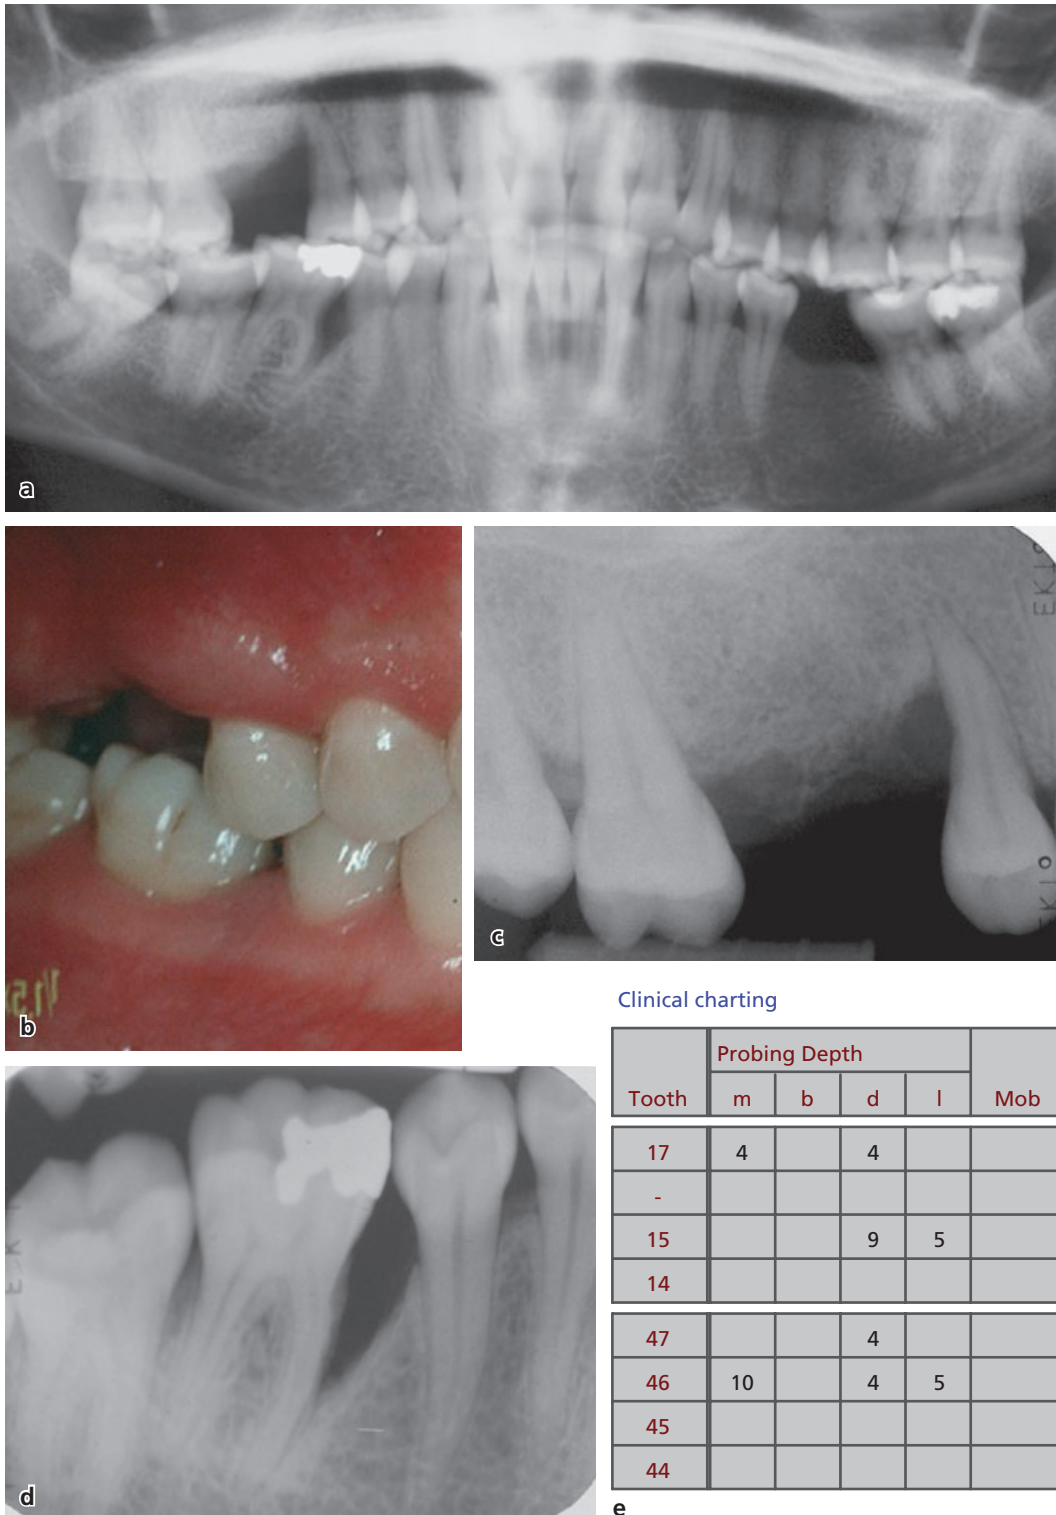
A 22-year-old female patient (A.A.) diagnosed as a case of aggressive periodontitis. (a–e) Clinical and radiographic status at the initial examination. Localized advanced periodontal lesions are diagnosed at teeth 15 and 46. (f) Radiographic view after periodontal and implant treatment. (g–j) Clinical and radiographic status 12 years after active treatment.
